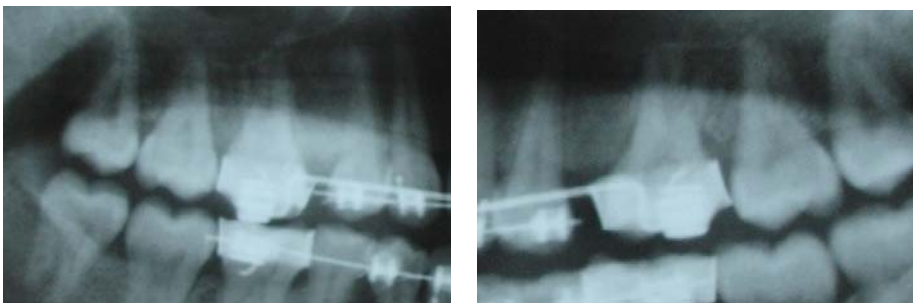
Case 3: Radiographs showing corrected position of the upper first molars.
